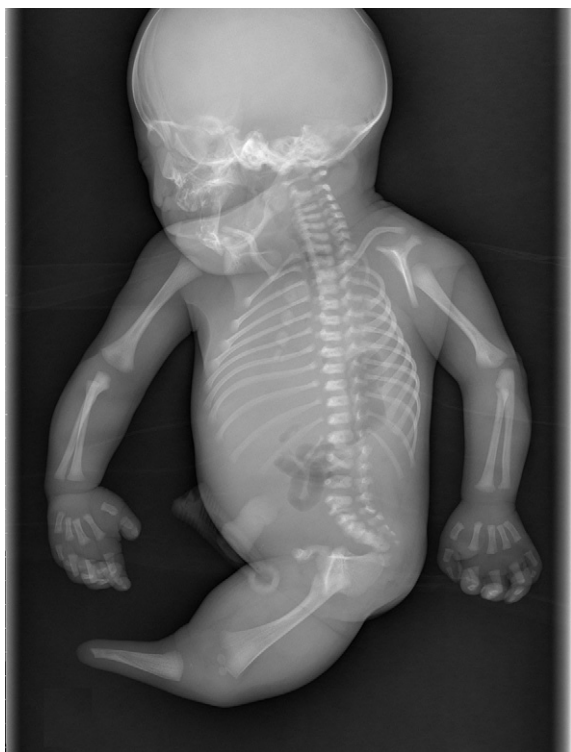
Postnatal X-ray showing sirenomelia with hypoplastic pelvis, absent right lower limb, absent left foot and an abnormal lumbosacral spine with sacrococcygeal dysgenesis.
